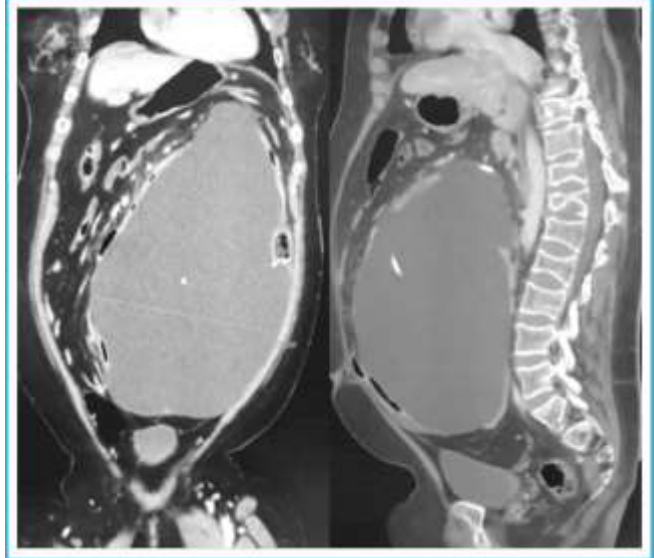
CT scan of the abdomen with contrast, coronal or sagittal views, showing large cystic, intra peritoneal, non-contrast enhancing collection around the distal end of the shunt.
